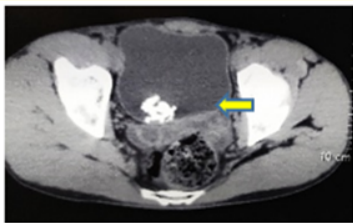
CT (Plain) of the Pelvis (axial view). The arrow shows a densely calcified irregular dependent mass 4 x 5 cm within the urinary bladder.
